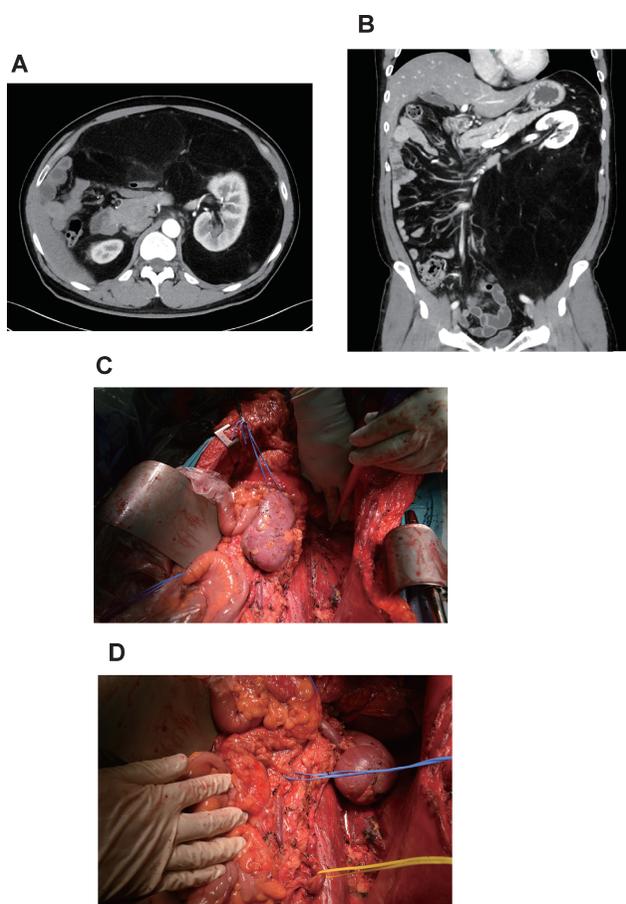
A case of a large left-sided retroperitoneal well-differentiated liposarcoma. Axial (A) and coronal (B) computed tomography images indicate a large fat-dense tumor surrounding the left kidney. The tumor was resected while preserving the left kidney (C, left kidney is inverted; D, left kidney is in the normal position). The upper and lower poles of the kidney were fixed to the retroperitoneum to prevent torsion of the kidney.
